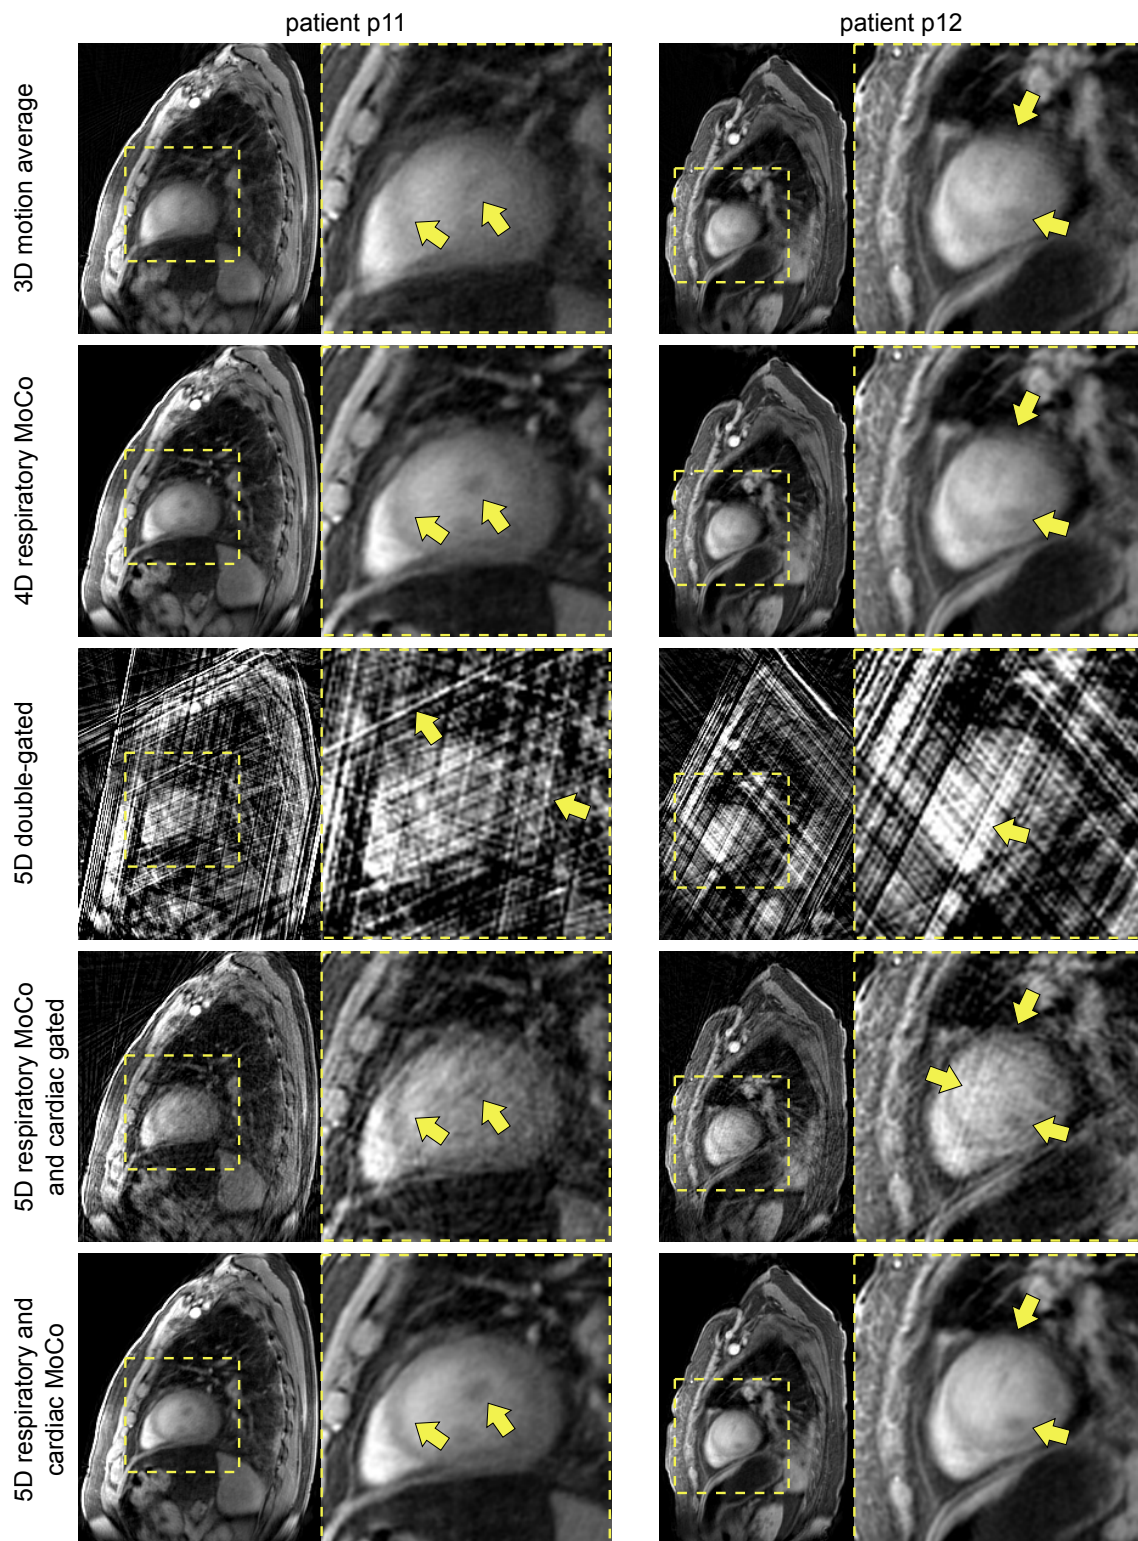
5D MRI study: MR image reconstructions of a 64-year-old male patient (p11, left) and of a 79-year-old female patient (p12, right) in sagittal orientation. A combination of end-exhale respiratory phase and a diastolic cardiac phase is shown.
